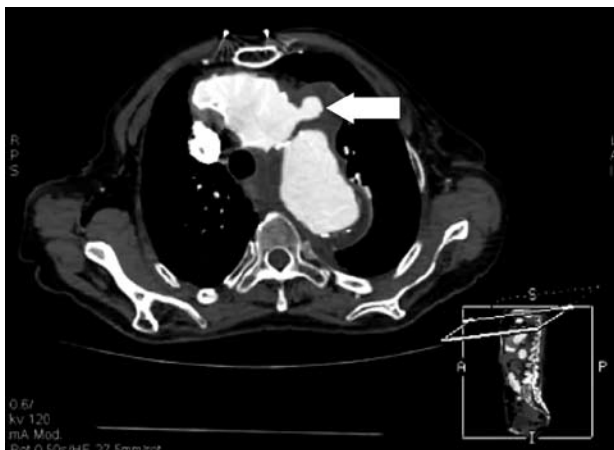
Chest computed tomographic scan showing the ulcer, which appears as a projection beyond the confines of the lumen (arrow), of the ascending aorta.
